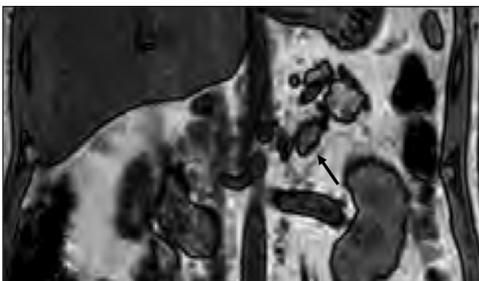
Out-of-phase coronal magnetic resonance image (TE 2.3 msec) demonstrates no significant signal loss (black arrow) from intralesional fat.
